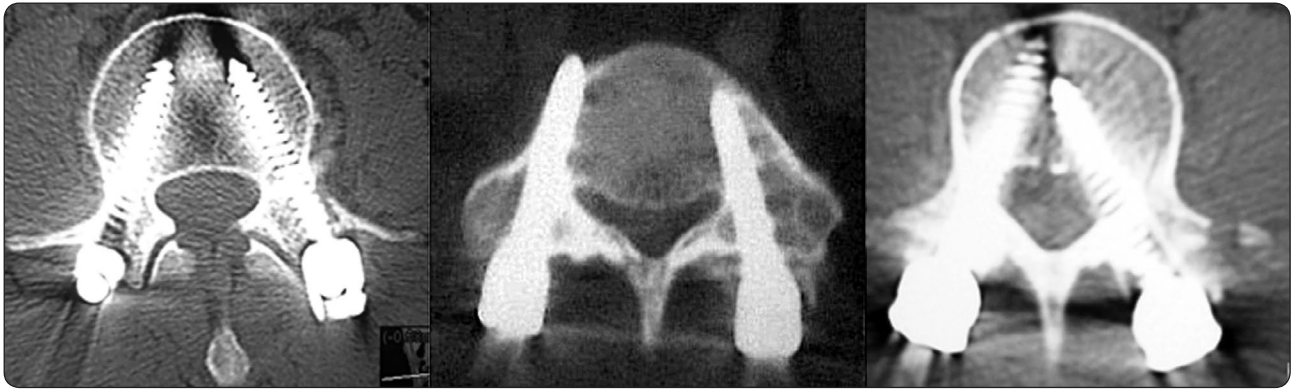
Axial cuts of bone window CT scan for different classes of screws showing: class 1 third lumbar pedicles screws bilaterally (left), a class 2 right fifth lumbar pedicle screw (middle) and a class 3 left third lumbar pedicle screw (right).
